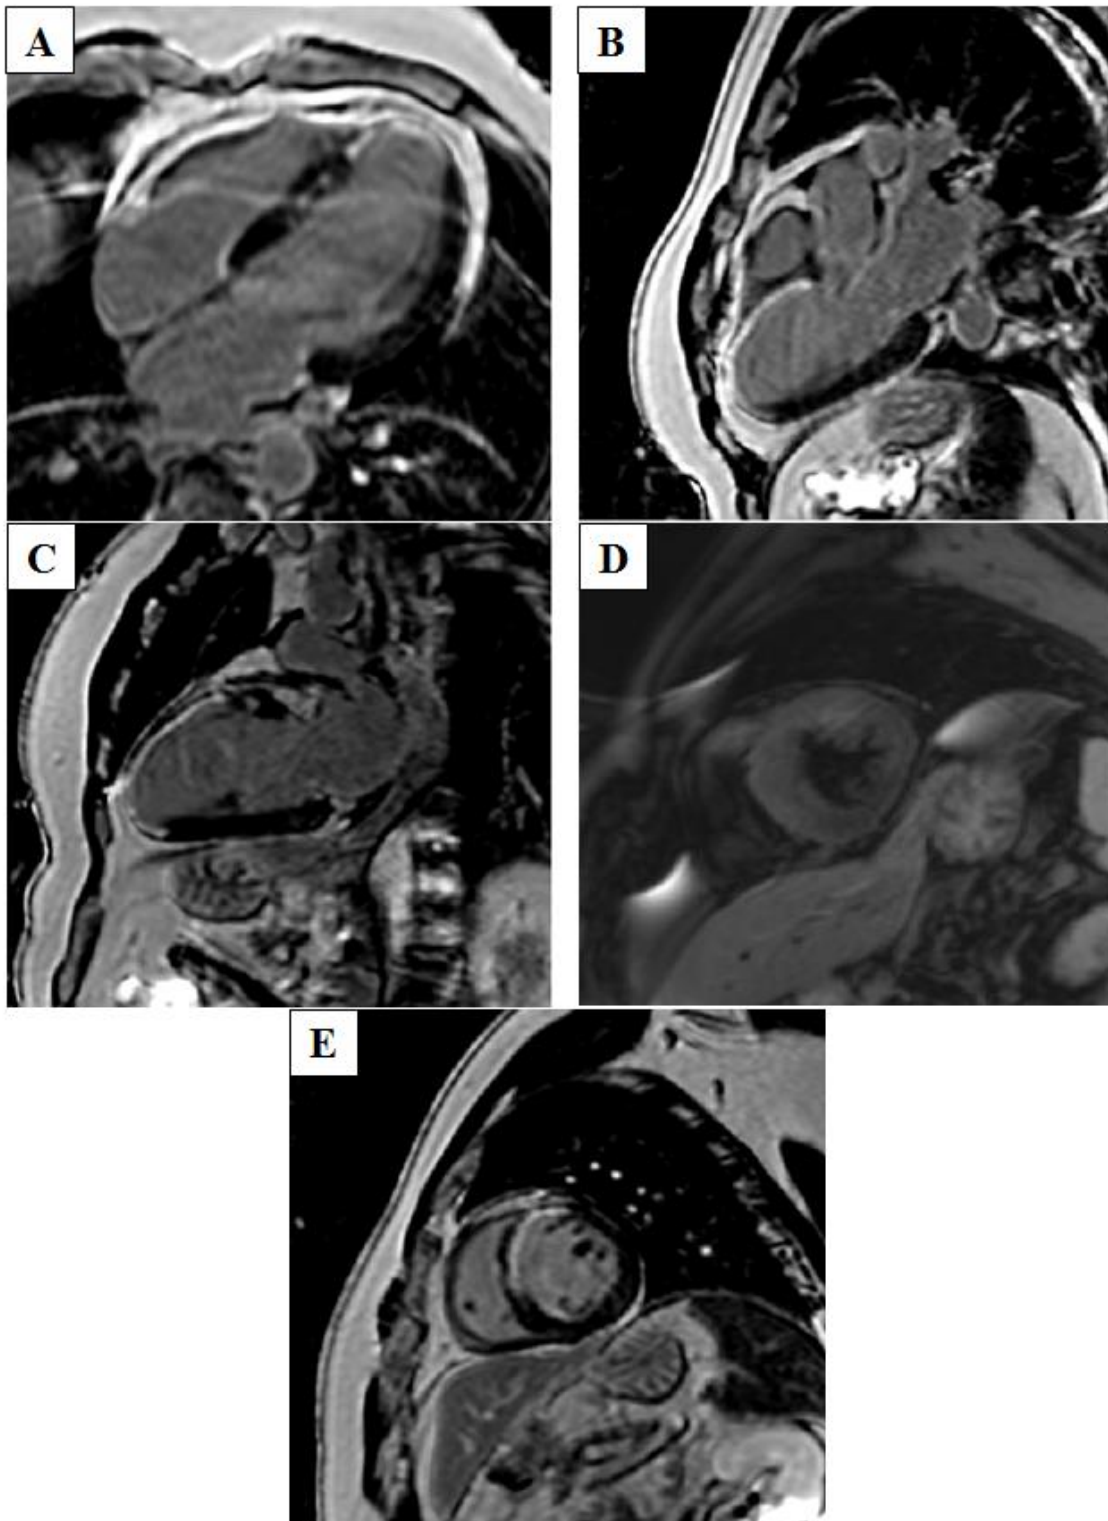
conventional CMR findings in acute ischaemic changes in case of inflammatory bowel disease. (a) Four chambers, (b) Three chambers, (c) Two chambers, (e) short axis views of late gadolinium enhancement (LGE) revealed subendocardial enhancement of anterior &anterio-septal myocardial wall at mid & apical levels as well as an apex. (d) A short axis view of T2-weighted imaging enables visualization of areas of myocardial oedema that denote recent insults.
